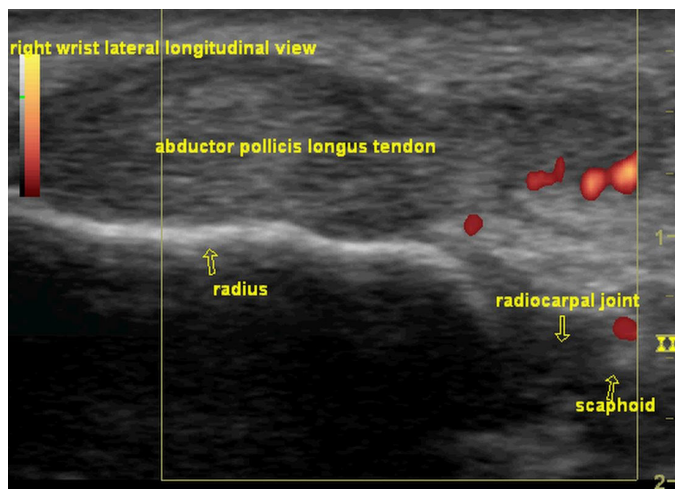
Lateral longitudinal view of the right wrist showing the 3 classic features of tendinosis of the APL. Doppler findings demonstrate increased blood flow around the tendon, suggestive of retinaculitis.
